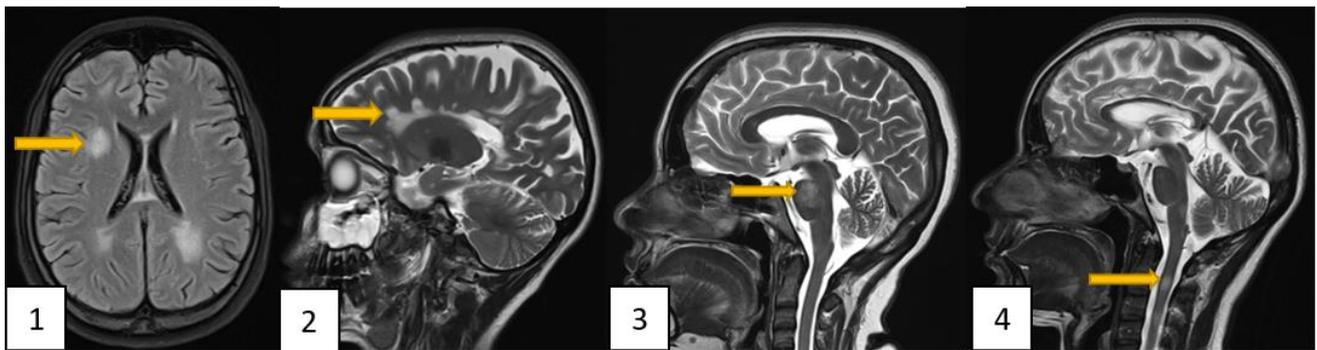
Lesion Locations. Axial FLAIR (1) and Sagittal T2W (2,3,4) images showing hyperintense lesions in juxtacortical white matter (1), periventricular white matter - Dawson's fingers (2), pons (3) and cervical cord (4).
